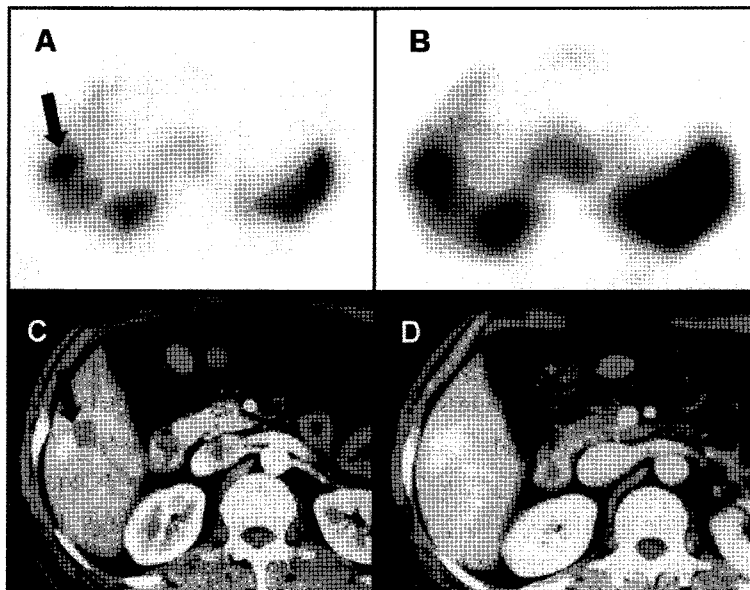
OSEM image (A) represents hot nodule (arrow) with oval shape and FBP image (B) showed larger hot nodule with round contour. On dynamic CT scan (C, D), oval shaped enhanced lesion (arrow) is noted on lower anterior portion (segment 5) of right lobe and this lesion has somewhat lobulated contour on posterior margin. Retrospectively, same contour can be found on OSEM images.
